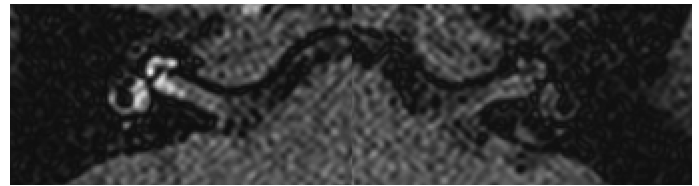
Case 2: picture of 3D-FLAIR sequence gadolinium-enhanced scan of a labyrinthine middle ear with a delay of 4.5 hours.
